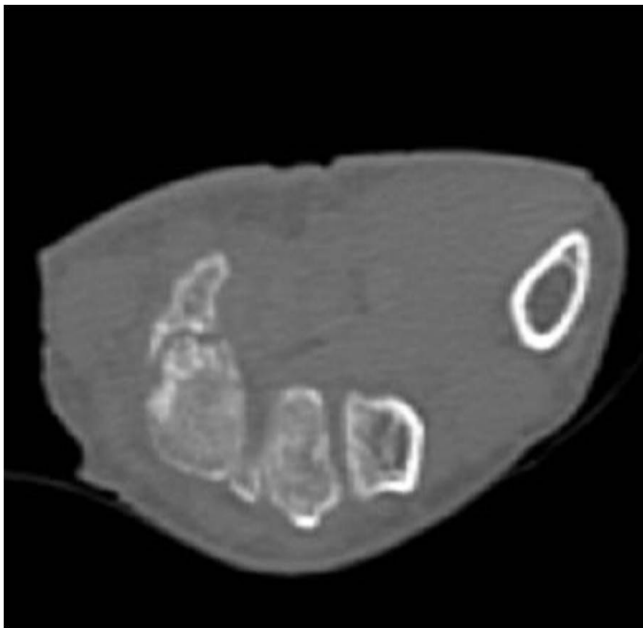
Axial (A) and sagittal (B) computed tomography images of an old nonunion of the base of the hamate.
